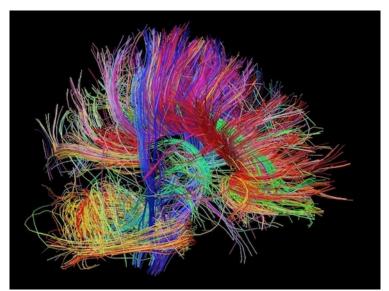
Figure of MRI using DTI (tractography) sequence of the cerebellum, bulb, bridge, midbrain and brain.
